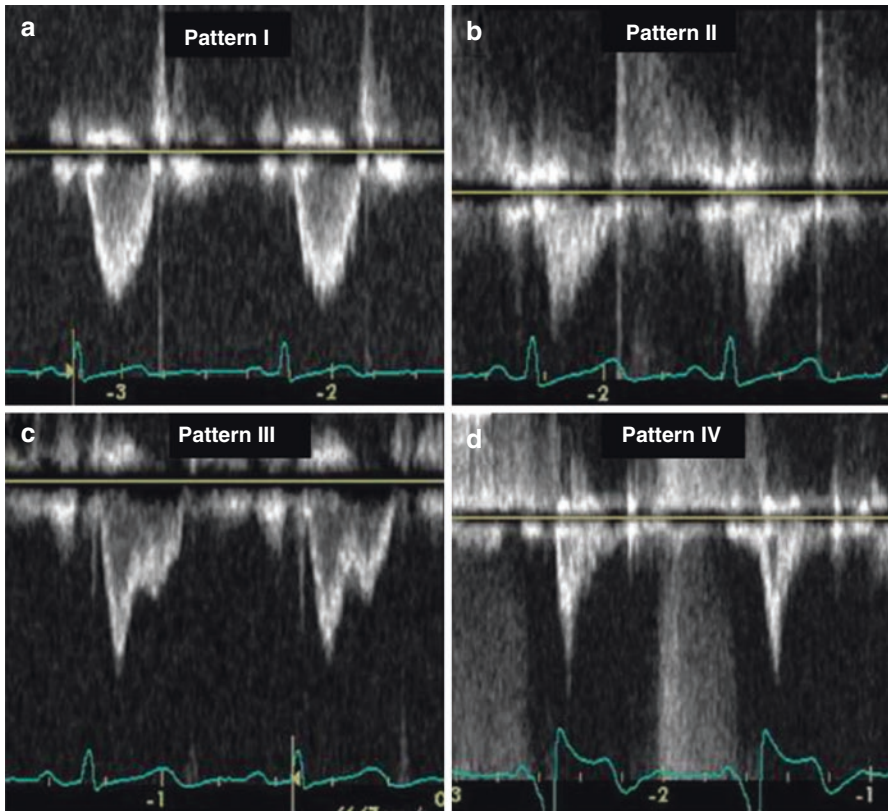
Pulsed wave Doppler pattern of the right ventricle outflow
